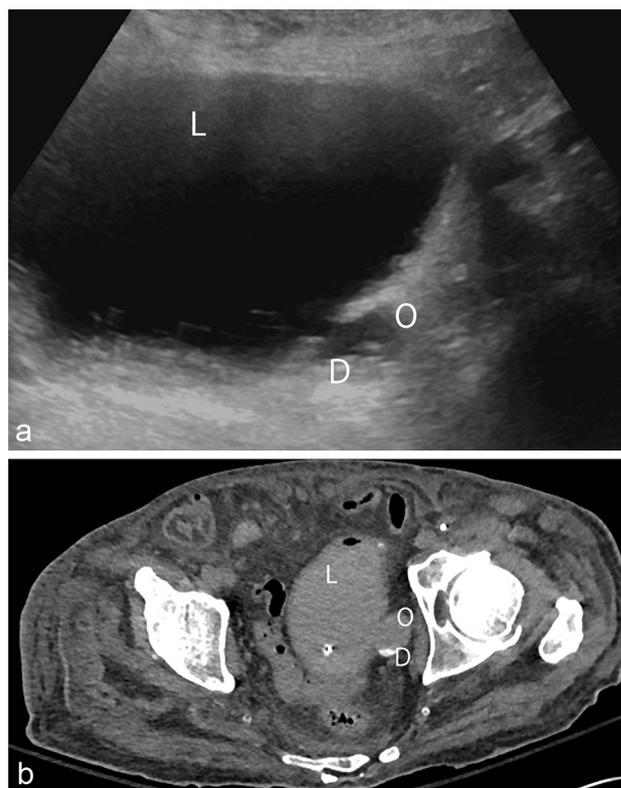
83-year-old male with chronic bladder outlet obstruction and a bladder diverticulum. a Transverse ultrasound view shows a distended bladder with irregular trabeculations along the bladder wall as well as a thin-necked bladder diverticulum containing layering debris. b Axial CT in the same patient confirms a diverticular outpouching with layering calcifications. A Foley catheter has now been placed, resulting in partial decompression of the bladder. *D* debris, *O* out-pouching, *L* bladder lumen
